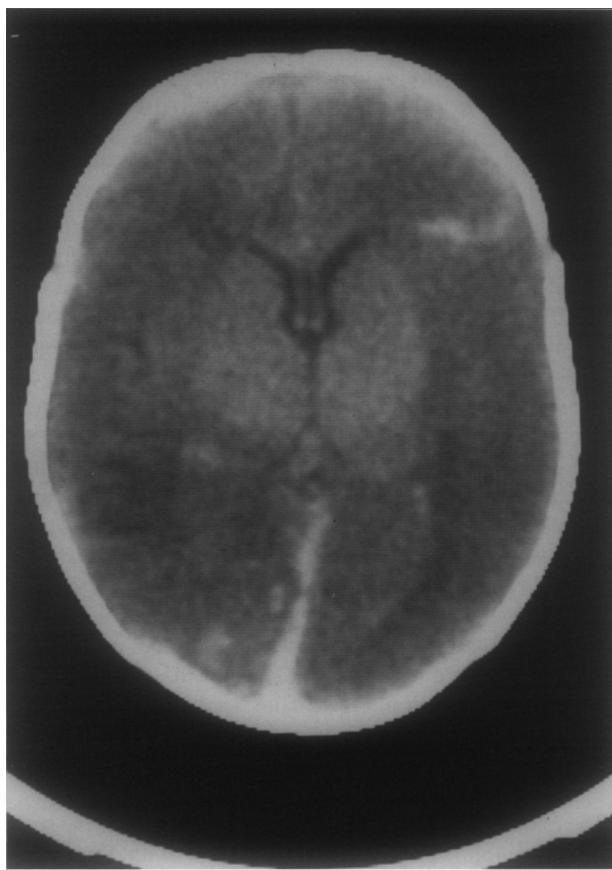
Axial non-enhanced CT through the brain of a shaken baby in non-accidental injury demonstrating both the Acute Reversal Sign of hypoxic-ischaemic encephalopathy and acute interhemispheric fissure subdural posteriorly along the falx. There are also several haemorrhagic lesions in the brain.
